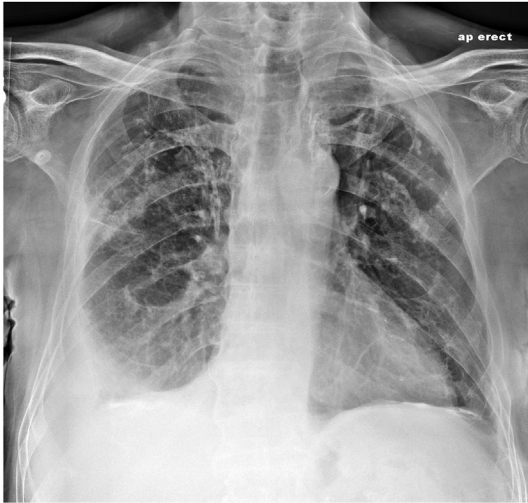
Chest-X-Ray showing moderate right-sided pleural effusion and bilateral calcified pleural plaques as well as diaphragmatic plaques.
